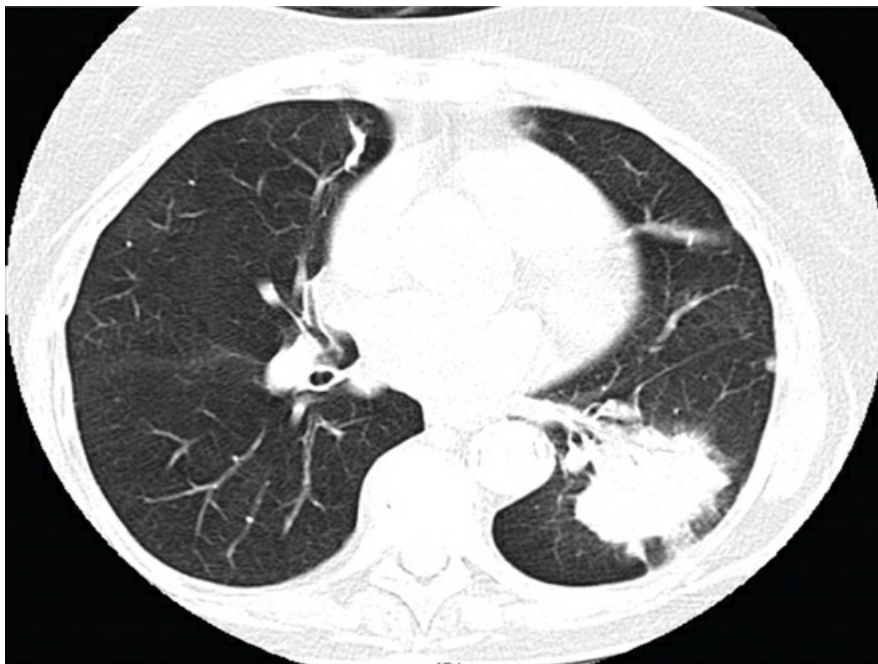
Chest CT cross-sectional (axial) scan image of the same patient in Fig. 21.2 demonstrating the appearance of the left lower lobe adenocarcinoma.
